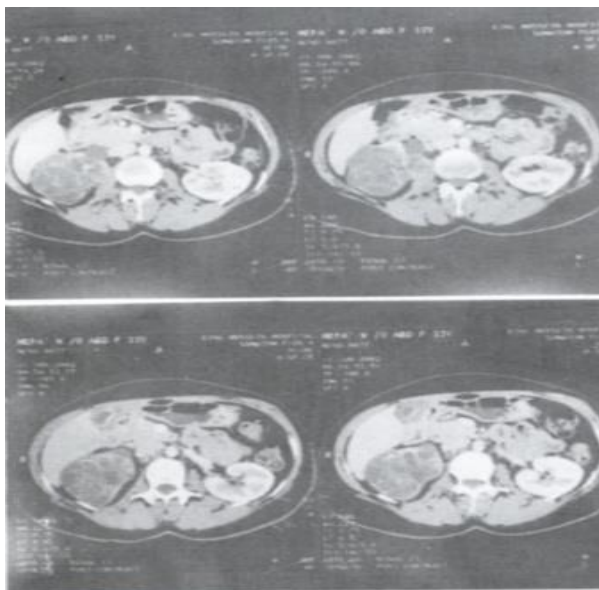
CT scan in case 1- showing the lesion.
